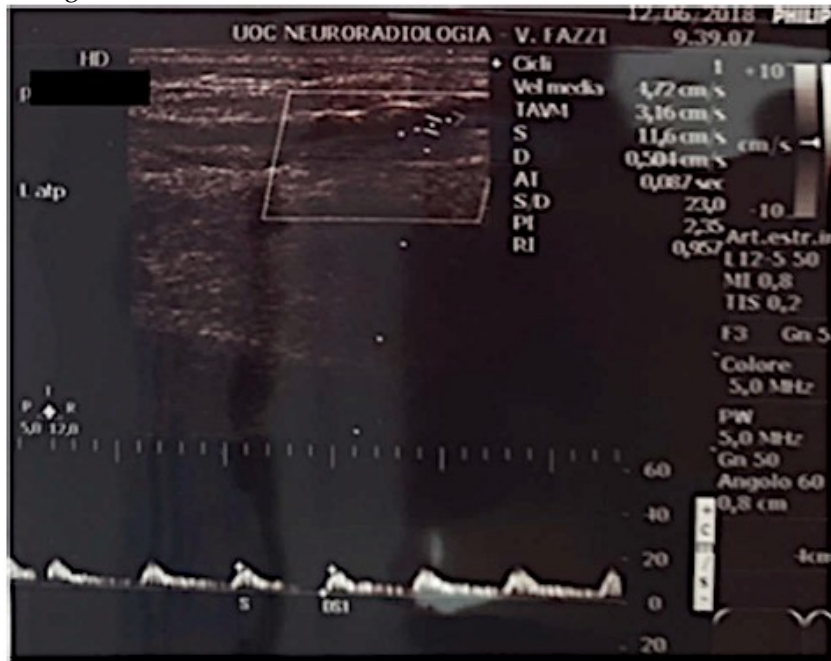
Findings from Color Doppler Ultrasound examination.(Note: on right limb diffuse atheromas but normal fluxes until tibials artery are present. Atheromas in lower limbs arterial axes. On left lower limb three-phase flow on common femoral artery and superficial femoral artery. Presence of calcific plaques with significant stenosis at Hunter cantal. After this point, bloody flows became demodulated in the popliteal artery, anterior and posterior tibial arteries).
